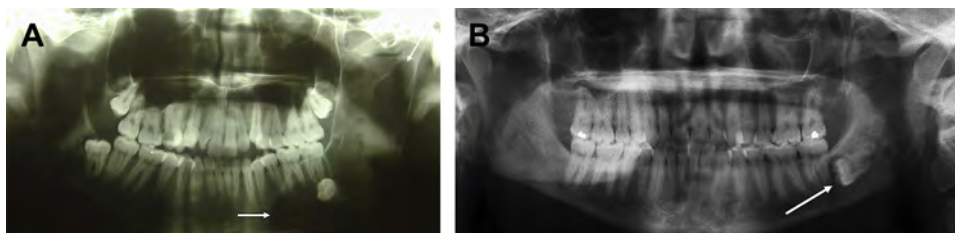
(A) Incidental finding on panoramic radiograph. Mandibular left M3 is not visualized on routine bitewings. Note the multilocular radiolucent lesion (arrows marking the anterior and posterior extent of the lesion) associated with the impacted mandibular left M3. (B) Incidental findings on panoramic radiograph. Mandibular left M3 is not visualized on routine bitewings. Note the radiolucent lesion (arrow) associated with the retained M3 in this 45-year-old man.
